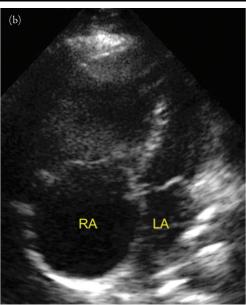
(a) Right ventricular hypertrophy (RVH) on a subcostal window. This window allows for the most accurate measurement of the RV free wall, as the ultrasound beam is perpendicular to the wall. A wall thickness >5 mm is consistent with RVH. (b) Right atrial (RA) enlargement on apical 4-chamber window. While measurements of the major and minor axis, as well as volumetric estimations of the RA can be performed, a quick method is to compare RA size with left atrial size.
